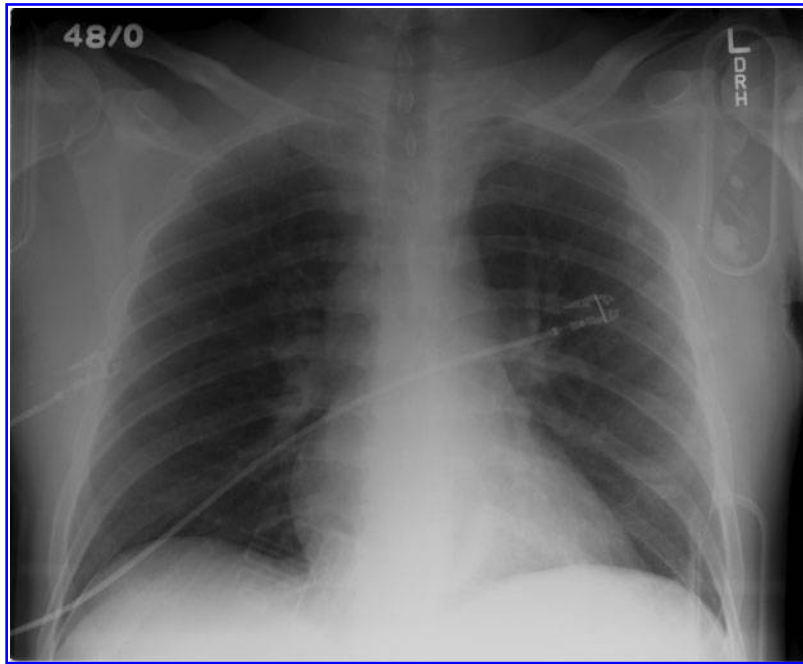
Chest radiograph on hospital admission post-accident revealing no traumatic injuries. Normal chest radiograph.
